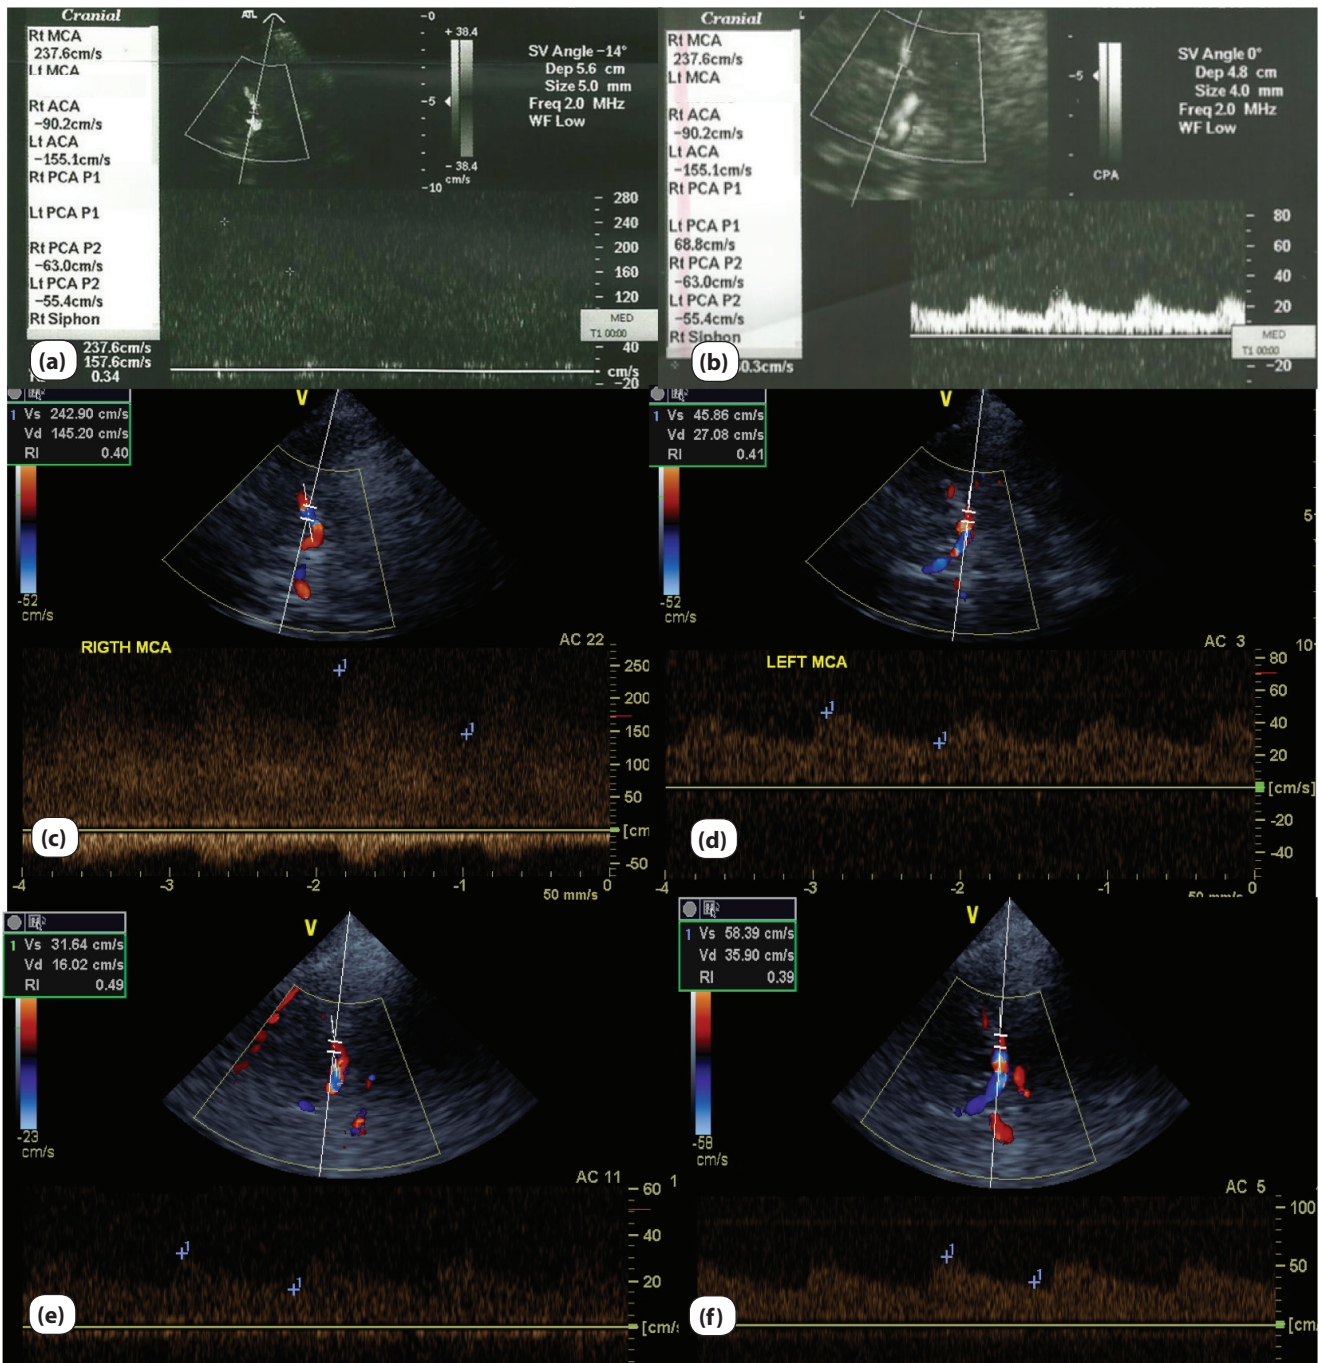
Transcranial color-coded sonography (TCCS) images. Admission: >50% proximal middle cerebral artery (MCA) stenosis (a) and MCA occlusion pattern (b); 3 months later: 70% right MCA stenosis with a prestenotic index=4 (c) and left MCA occlusion pattern (d); 1 month later: right (e) and left (f) MCA occlusion pattern.
